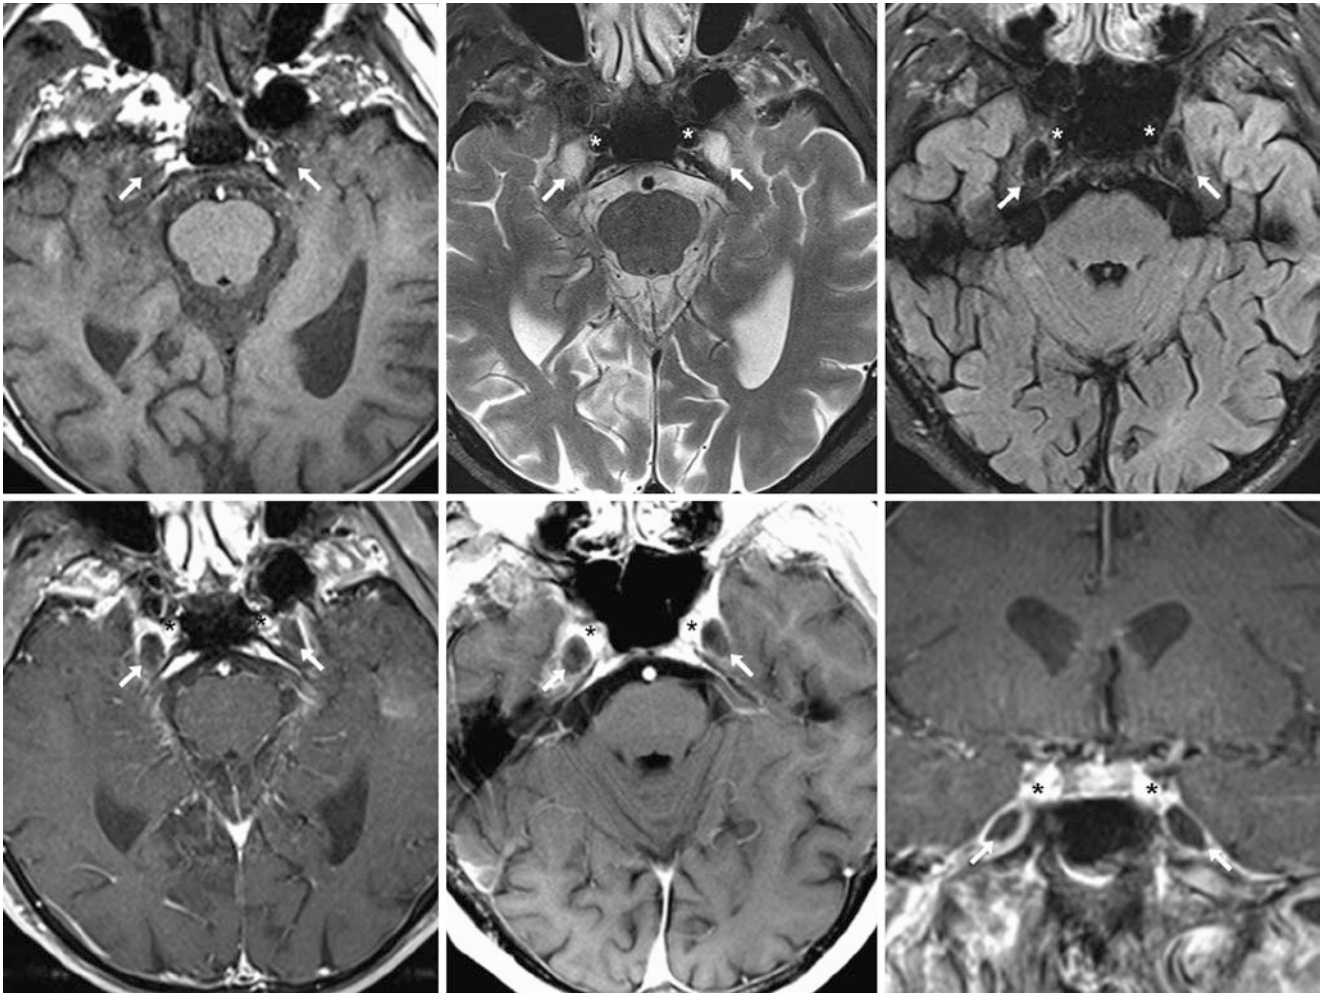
A 78-year-old patient with normal but prominent Meckel caves (arrows) bilaterally on a 3 T MRI with axial T1WI (top left), T2WI (top middle), FLAIR (top right), and postcontrast axial fat suppressed T1WI (bottom left) as well as non-fat suppressed axial (bottom
